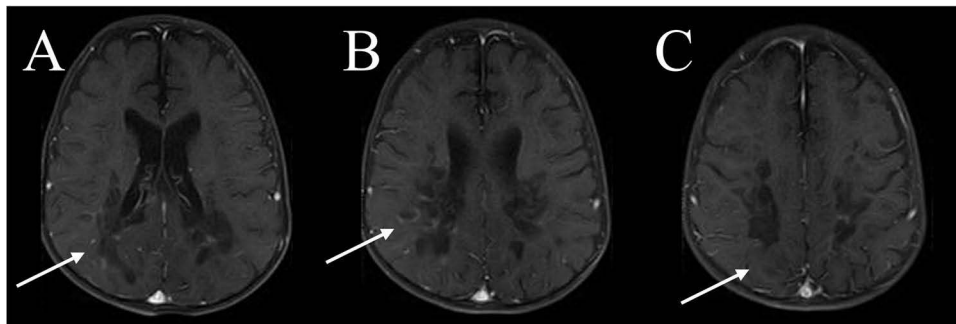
Postcontrast study with gadolinium-enhanced MRI of the brain; (A–C) show mild focal linear enhancement on both sides with greater enhancement on the right side (marked by white arrows).
